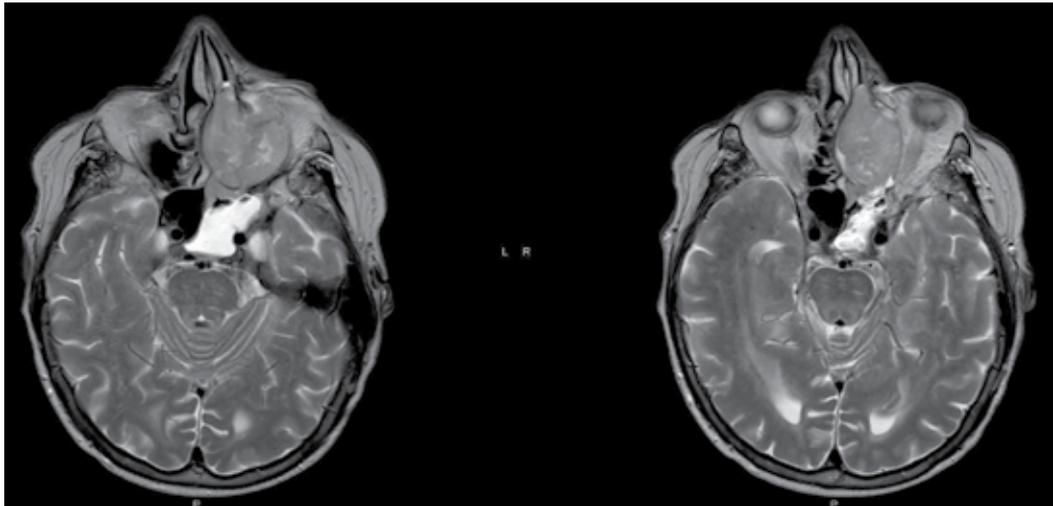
Preoperative axial T2-wieghted preoperative MRI showing primary sinus melanoma with left orbital compression in an 86 year old gentleman. Patient underwent endoscopic removal with aide of a small subconjunctival incision for palliative debulking of the lesion without globe removal.
